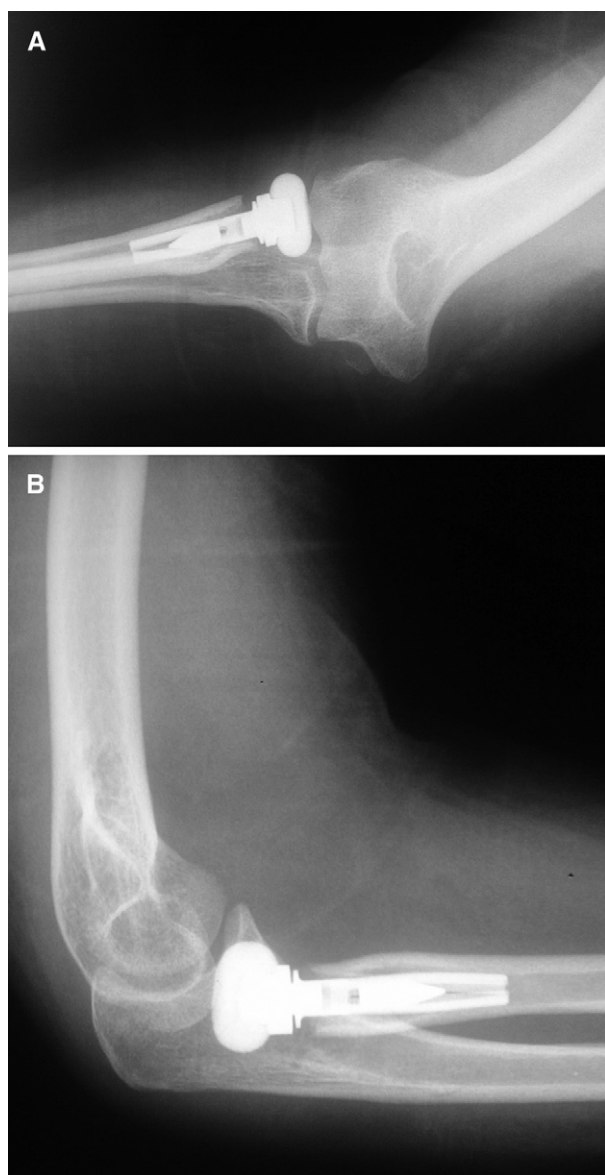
(A) Anteroposterior and (B) laterolateral radiographs of the elbow show the postoperative result after radial head replacement with MoPyC prosthesis.
